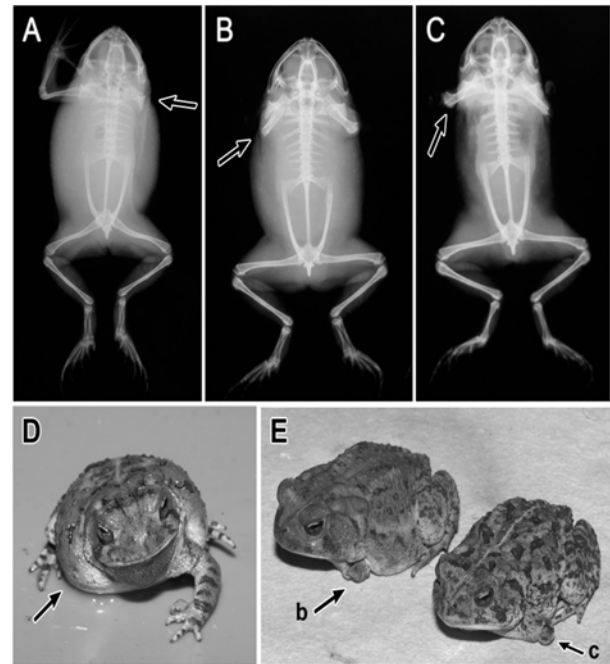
Radiographs showing amelia (A), and bilateral ectromelia (B and C). Photographs D and E are the corresponding toads for radiographs A,B, and C. Missing and partial limbs shown in photographs D and E (b and c).
